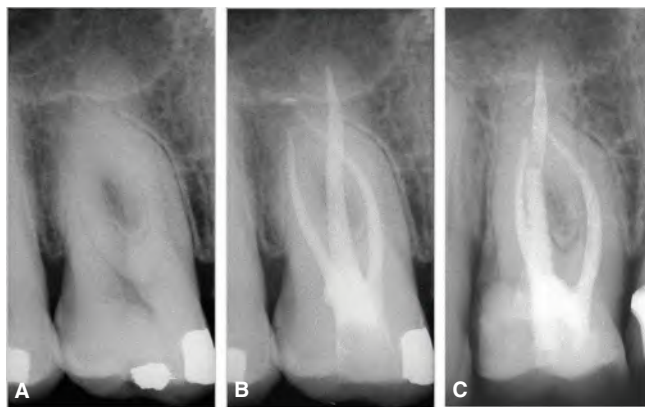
Nonsurgical endodontic treatment in a maxillary first molar. Patient presented with acute clinical symptoms of pulpitis. A. Preoperative radiograph. B. Immediate postoperative radiograph. C. Five-year follow-up radiograph. The tooth is asymptomatic and has been restored to function.
